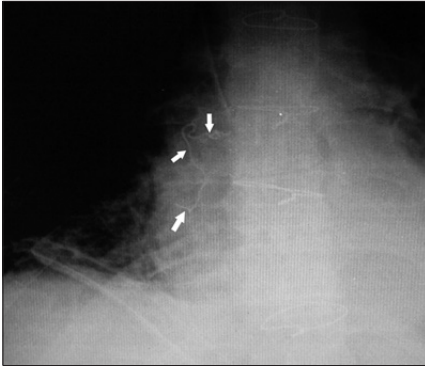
Plain radiograph of the chest revealed a hypodense mass with a thick peripheral rim, characteristic whirl-like pattern
